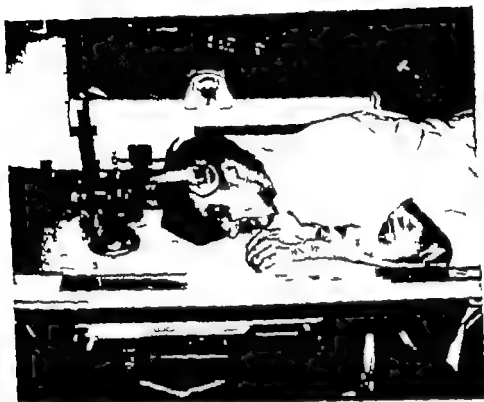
Fixation of head during exposure of the polytome x-rays.
